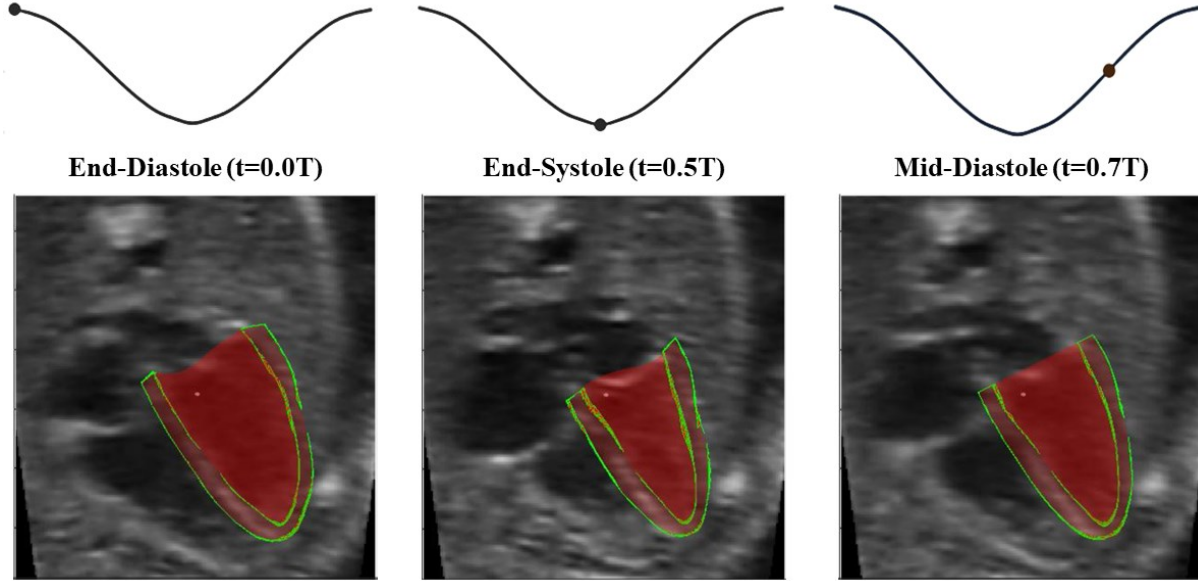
Reconstructed fetal LV superimposed onto a cross-section of the ultrasound image, at 3 time points in the cardiac cycle, where T is the duration of the cardiac cycle. Red – signifies the 3D LV reconstruction, green – identifies the portions of the 3D reconstruction that are in the image plane shown.
